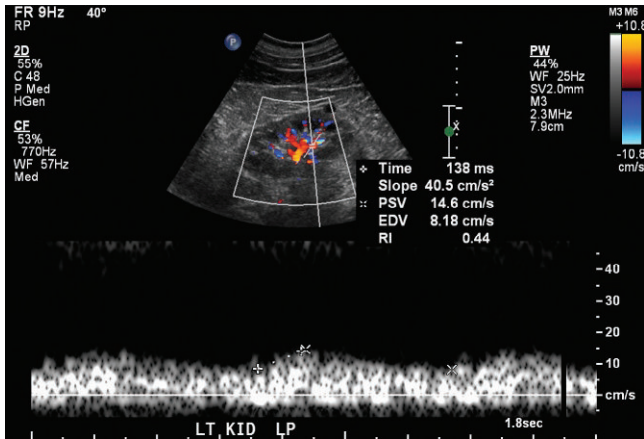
Spectral Doppler of left lower pole intrarenal artery. There is a tardus parvus waveform. The time to peak systole is delayed, 138 ms. There is little difference between systole and diastole. The waveform indicates upstream obstruction.
